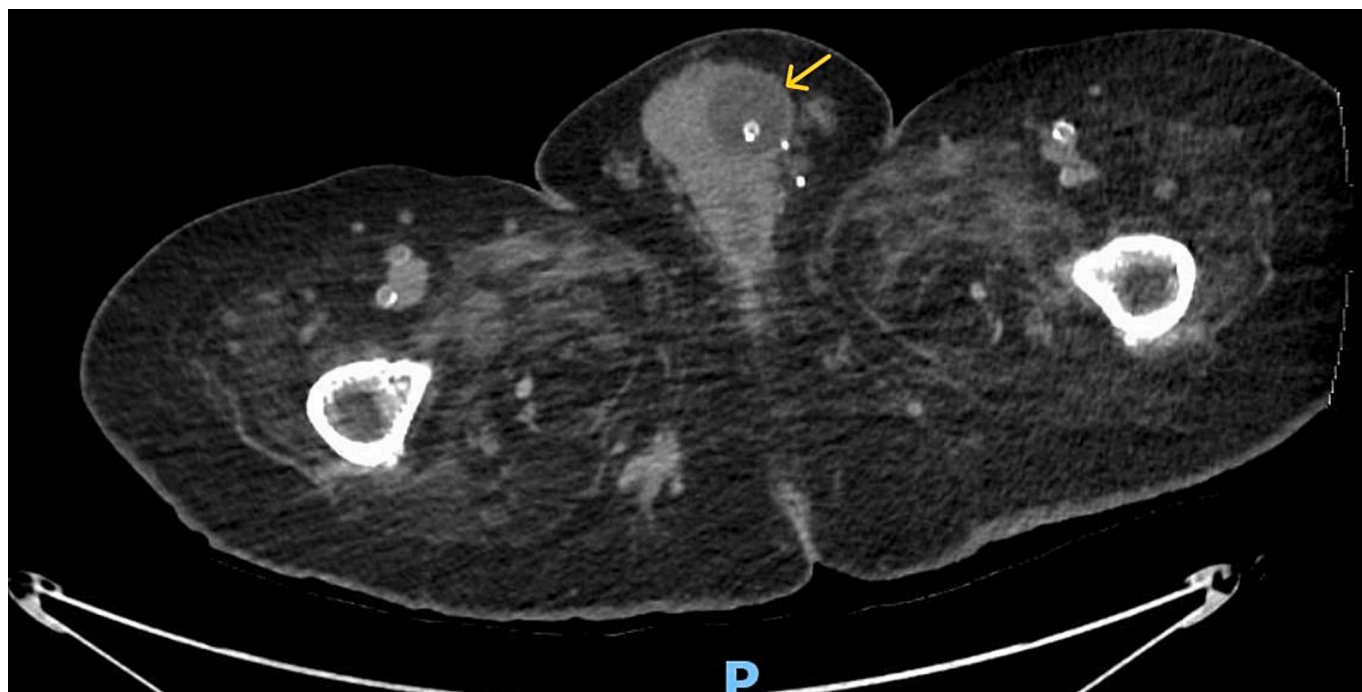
CT of pelvis (axial view) shows the balloon of the Foley catheter inflated in the urethra at penis base (arrow).
